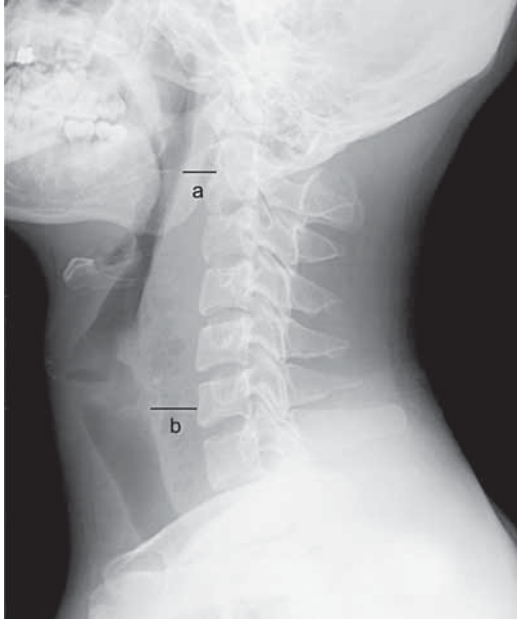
lateral neck radiograph reveals the thickness of the prevertebral soft tissue of the C-spine increases with obvious gas accumulation. (a=1.41cm, b=2.39cm)
